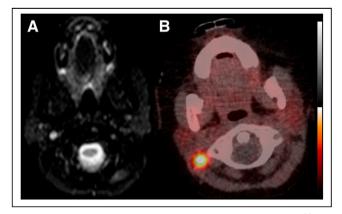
Persistent right-neck lymph node uptake on ⁶⁸Ga-DOTATATE PET/CT (B) that has normal size and other morphologic criteria on correlative short-tau inversion recovery MRI (A).
